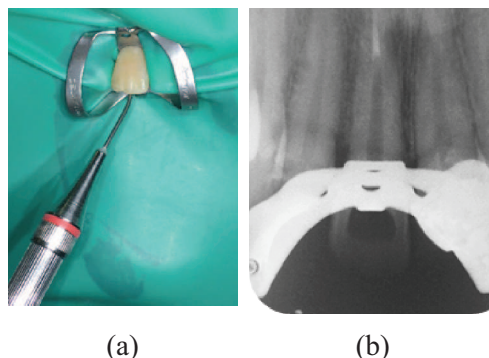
(a) MTA application using Micro Apical Placement systems; (b) The overview of periapical radiograph applications of MTA on apical third tooth 11.
